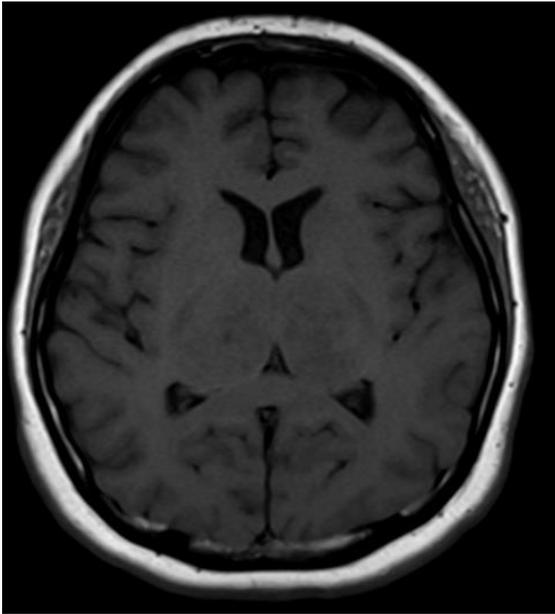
T1-weighted image shows isointensity of both enlarged thalami.
